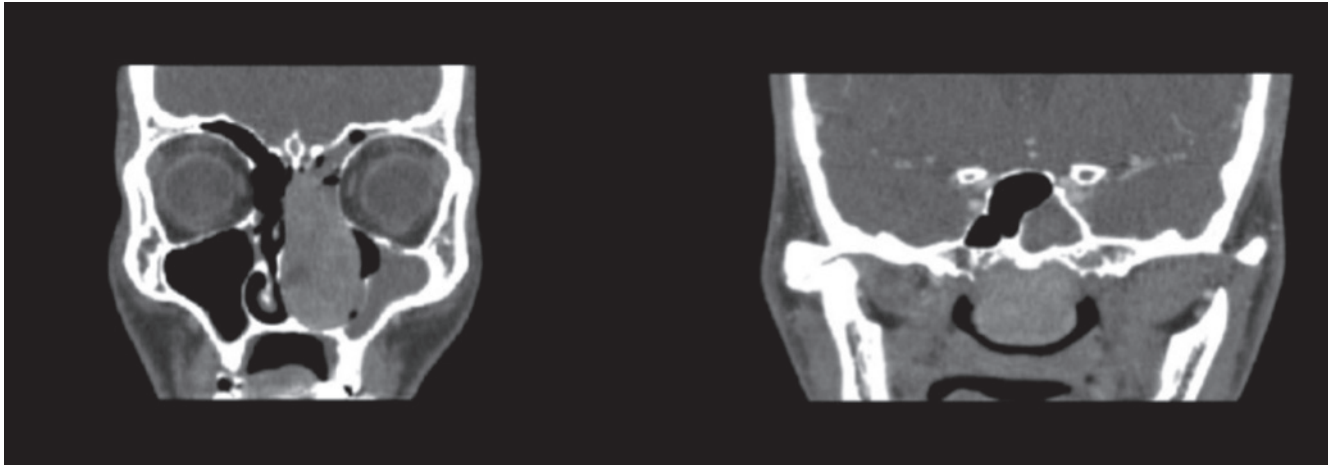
Same patient. CT coronal sections.
